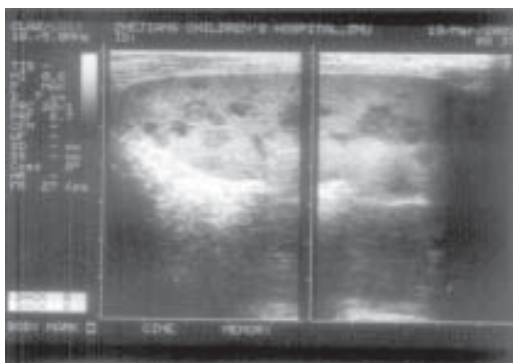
Abdominal ultrasound examination showing many small, hypoechoic, rounded, wedge-shaped and well-defined nodules diffusely in spleen.
